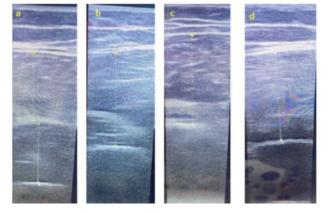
Locations of ultrasonography measurements on the anterior thigh
